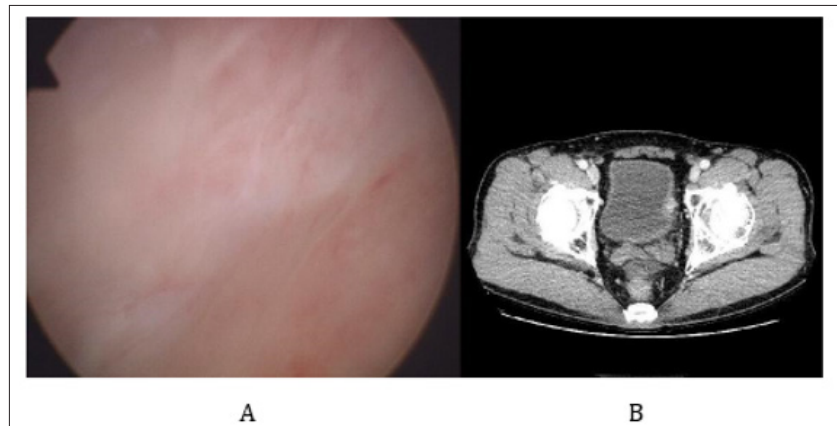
Cystoscopy and computed tomography 6 months after initial transurethral resection of bladder tumour.
